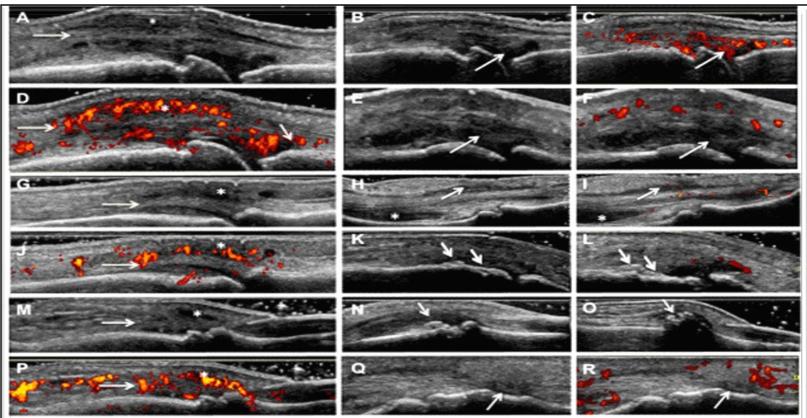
Ultrasound lesions in dactylitis. Longitudinal scans of digital extensor tendons in GS (A,G,M) and in PD (D, J, P) US showed extensive peritendinous inflammation. Note the tendor thickening (A,G,M), the loss of fibrillar pattern (A,G) and hypoechogenicity (A,M) of the extensor tendon. Digital extensor tendonitis or paratenonitis at the MCP joint (A,D), at the PIP joint (G,J) and at the synovio-entheaseal complex at the DIP joint (M,P) (arrows in panels A,D,G,J,M,P indicate digital extensor tendon and asterisks indicate anechoic or hypoechoic material around the dorsal extensor tendon with PD signals). Longitudinal US scans of MCP and PIP joints in GS (B,E) and PD C,F) mode. PD positive (C) and PD Doppler negative (F) synovitis at the MCP joint (B,C) and at the PIP joint (E,F). Note the pericapsular PD signals in panel F (arrows in panels B,C,E,F indicate synovial hyperthrophy) with (C) or without (F) PD signals. Longitudinal scans of digital flexor tendor (H,I) at the PIP joint. Tenosynovitis of flexor digital tendon is depicted in GS (H) and PD (I) mode. Note the hypoechoic thickened tissue (arrows) with fluid (asterisk) inside the tendon sheath (H) with few synovial and intra-tendinous PD signals (I). Osteoproliferation at the PIP joint (K,L) and at the DIP joint (N,O) depicted in longitudinal scans. Enthe sitis of digital flexor tendon is depicted in GS (Q) and PD (R). The latter finding is rare (arrows indicate enthe sitis).
